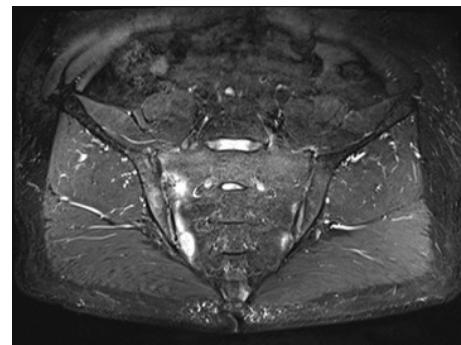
Coronal T2 fat-suppressed MRI showing bilateral subchondral bone marrow edema of the sacroiliac joints, right greater than left, consistent with active inflammatory sacroiliitis.
